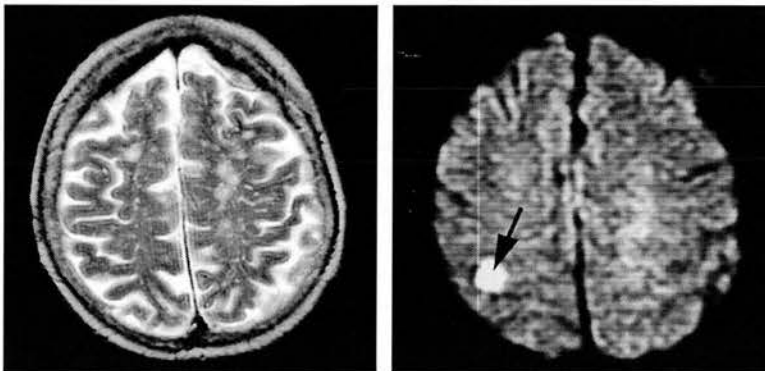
The DWI scan showed a small cortical lesion (not seen on structural MR)
